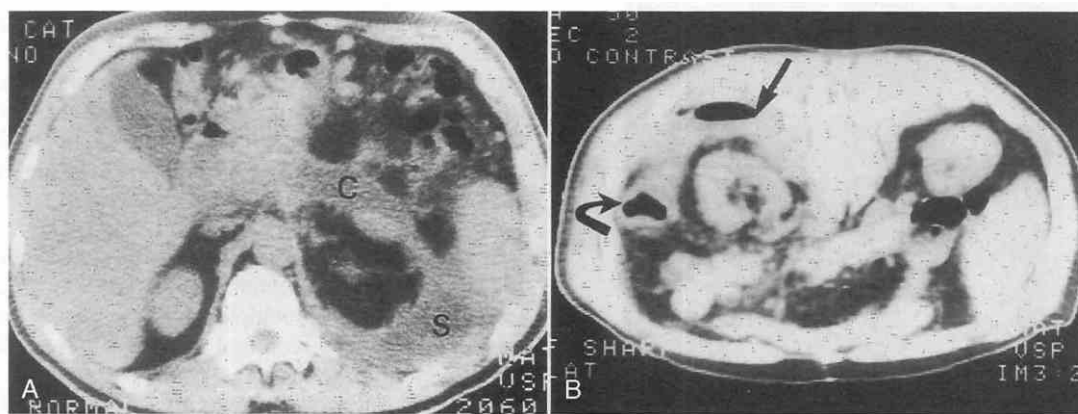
A, Baseline CT scan of a patient with a pseudocyst in whom a colonic fistula developed. This scan shows a pseudocyst (C) with an extension to the splenorenal ligament (S). B, Second scan taken 2 days later with the patient prone shows air (arrow) in the posterior fluid collection and fluid extending around the colon (curved arrow).
